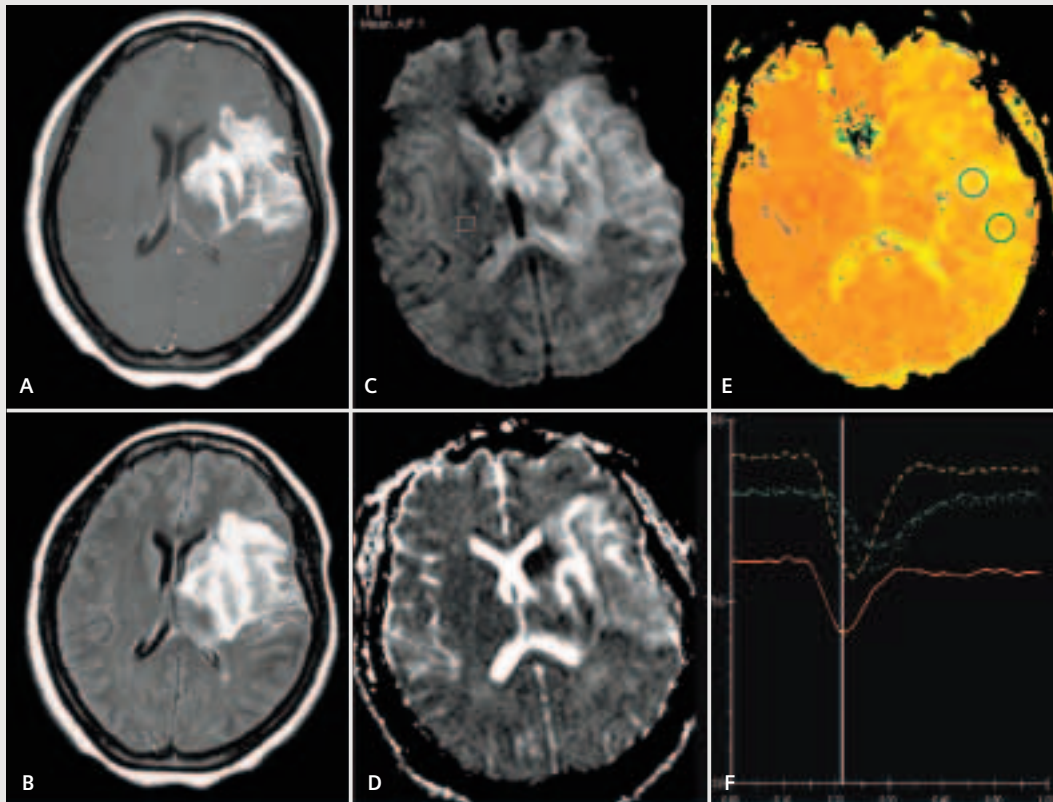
45-year-old-woman presenting with a 10-day history of right arm and leg weakness: The clinical and final diagnosis was a left middle cerebral artery territory stroke, however conventional MRI, including diffusion weighted imaging was inconclusive. A: Axial T1-weighted image post-gadolinium demonstrates abnormal enhancement in the left hemisphere involving gray and white matter. B: Axial FLAIR image demonstrates abnormal T2 signal as well as some mass effect. There is a small amount of edema. C: Diffusion-weighted image ($B = 1000$) demonstrating some increase in signal. D: The ADC map also shows areas of increased signal, which may represent "T2-shine-through effect" as well as some areas of decrease signal, which may represent true diffusion restriction. These findings on diffusion are sometimes also seen in very heterogeneous high-grade gliomas. E: Gradient-echo axial perfusion MRI with mean transit time (MTT) color overlay demonstrating prolongation in the MTT throughout the entire middle cerebral artery (MCA) territory in keeping with left MCA ischemia. F: Signal intensity versus time curves color coded to the 4 ROIs placed on the MTT maps, demonstrating prolongation in MTT in the green, blue and to a lesser extent the yellow ROIs. The red ROI indicates normal MTT in the contralateral hemisphere. The delay in MTT and reduced CBF^* in the MCA distribution is in keeping with a stroke. Data were acquired on a 1.5T MAGNETOM Symphony.
